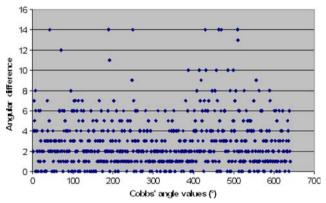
Graphic representation of the difference between the measures using  $30 \times 90$  cm and  $14 \times 42$  cm radiographs
